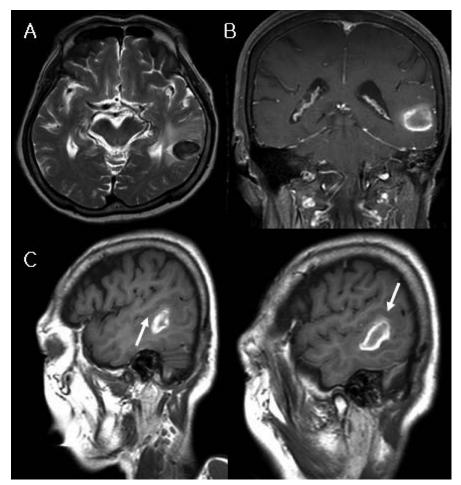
weighted axial (A), T1-weighted coronal (B), and sagittal (C) MRI shows an intracerebral hemorrhage involving the middle temporal gyrus. Arrows in C indicate superior temporal sulcus.
